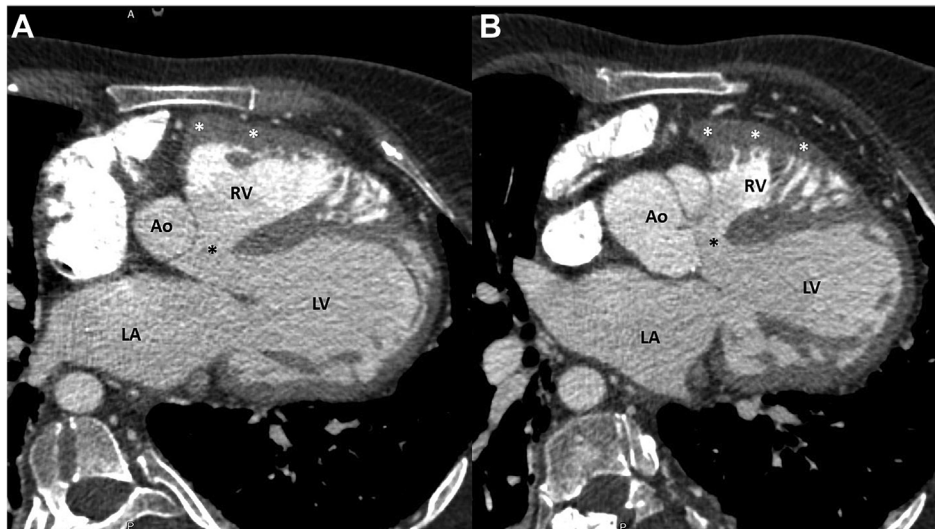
Unrepaired tetralogy of Fallot. Sequential axial slices from a gated cardiac CT study demonstrating 3 of the 4 features of tetralogy, including large subaortic VSD (asterisk), overriding aorta (Ao), and right ventricular (RV) hypertrophy (white asterisks). CT, computed tomography; LA, left atrium; LV, left ventricle; VSD, ventricular septal defect.
